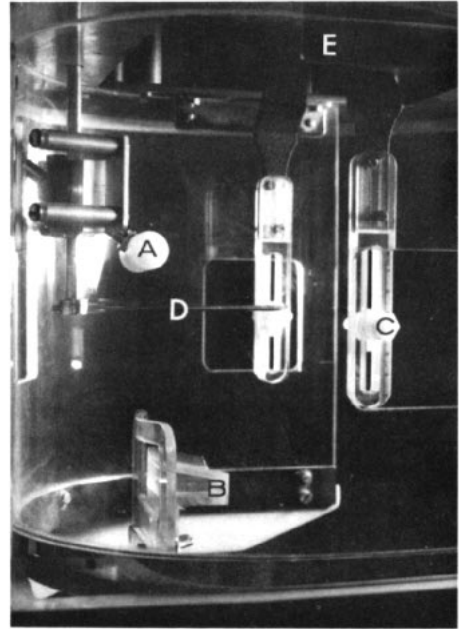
Cephalostat designed for the Orthopantomograph. A, nasion rest; B, calibrated chin rest; C, calibrated adjustable ear rod assembly; D, infra-orbital marker; E, mechanism to adjust ear rod assembly anteriorly, posteriorly, medially, and laterally.
